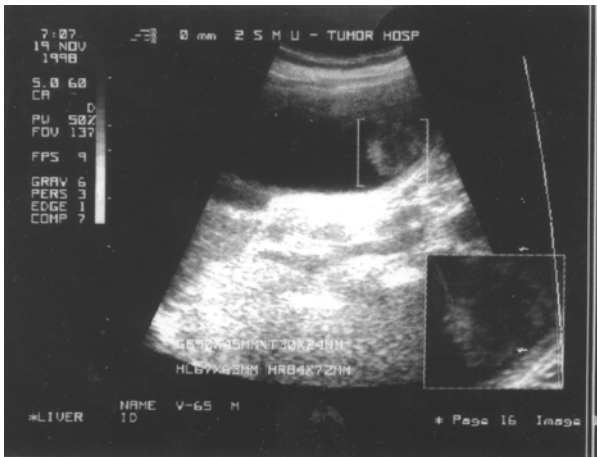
Case 1, male, 65 years old, the fungoid of carcinoma of gallbladder by ultrasonography
